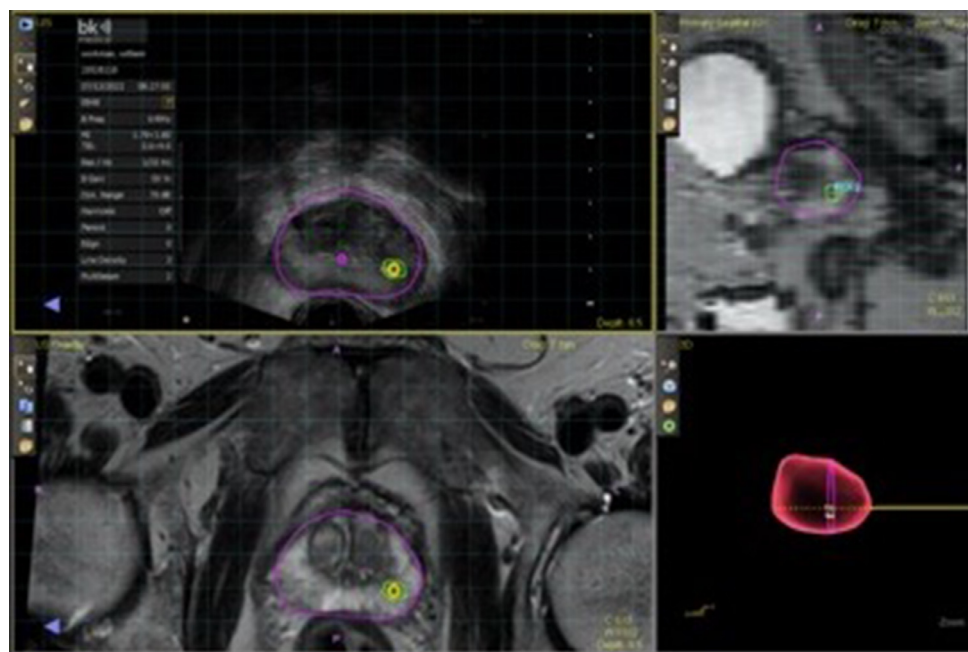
The target lesion in the left peripheral zone “fused” to the ultrasound images to allow for MRI fusion targeted biopsy. (Color version of figure is available online.)
